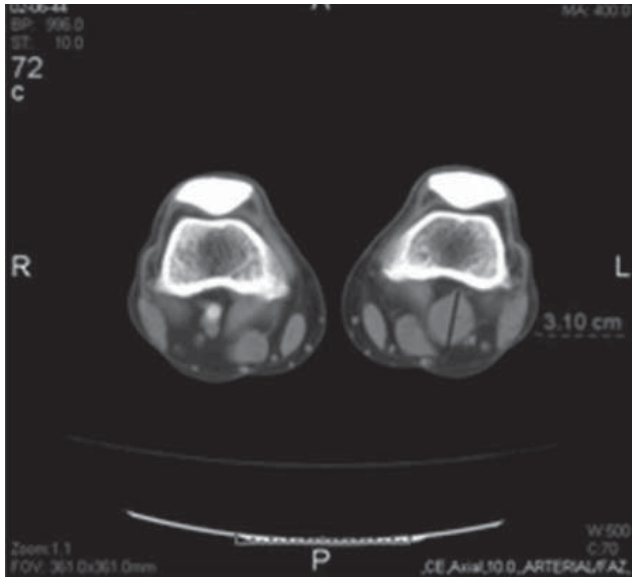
Poorly distal perfusion was observed after the PA aneurysm on computed tomography angiography.
